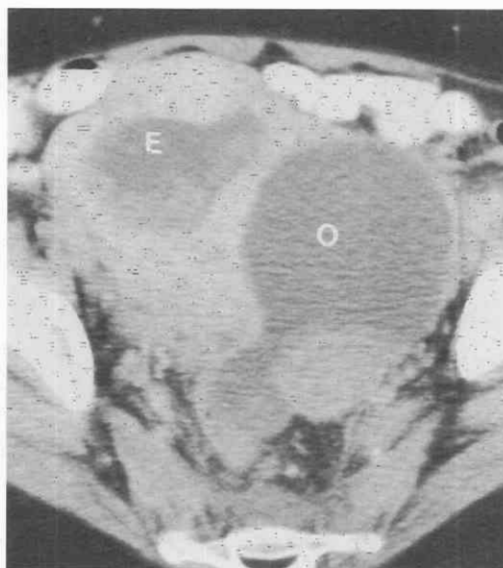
Endometrioid cancer. CT scan through the pelvis shows coincident tumors of the endometrium (E) and left ovary (O).
